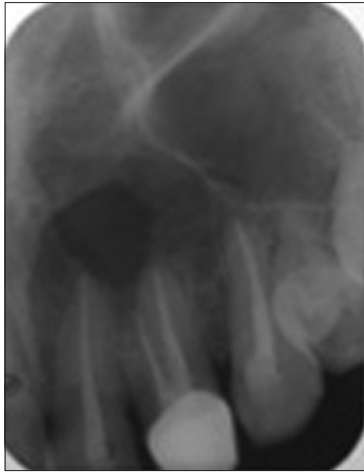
Radiograph after 1-year showing healing
